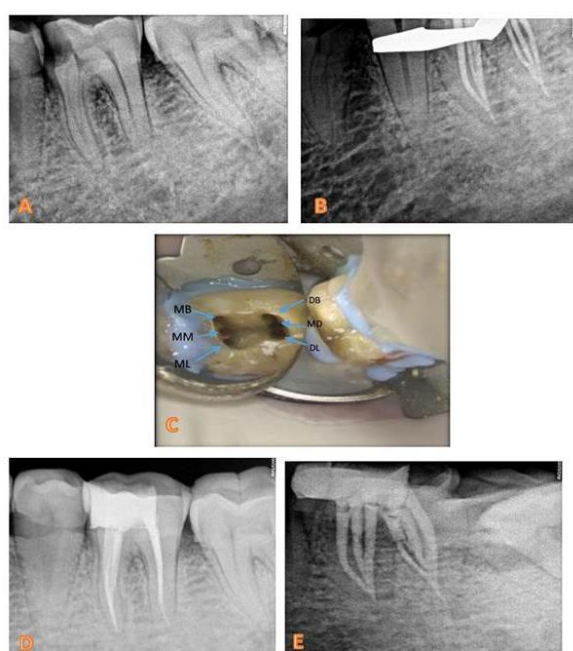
A to E : (A) Preoperative radiograph of mandibular first molar showing caries extension up to the pulp and widened periodontal ligament space. (B) Master cone radiograph showing gutta-percha in six separated canals. (C) Access cavity showing three mesial and three distal canals. (D) Radiograph after obturation. (E) Radiograph with different angle showing six obturated canals.
